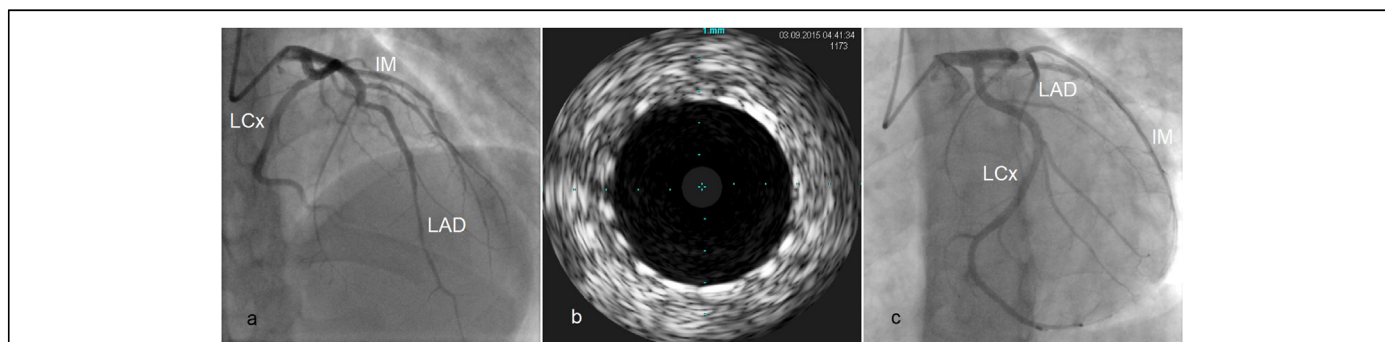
(a) Angiographic image (LAO 0° CRAN 40°) of the final result after stents deployment; IM, the intermediate branch; LAD, left anterior descending artery; LCx, left circumflex artery. (b) Intravascular ultrasound image of self-expanding stent apposition in the 6-mm-wide left main coronary artery. (c) 3-month control angiography (LAO 27° CAUD 20°) showing stents' patency and the unobstructed LCx and IM ostia.
